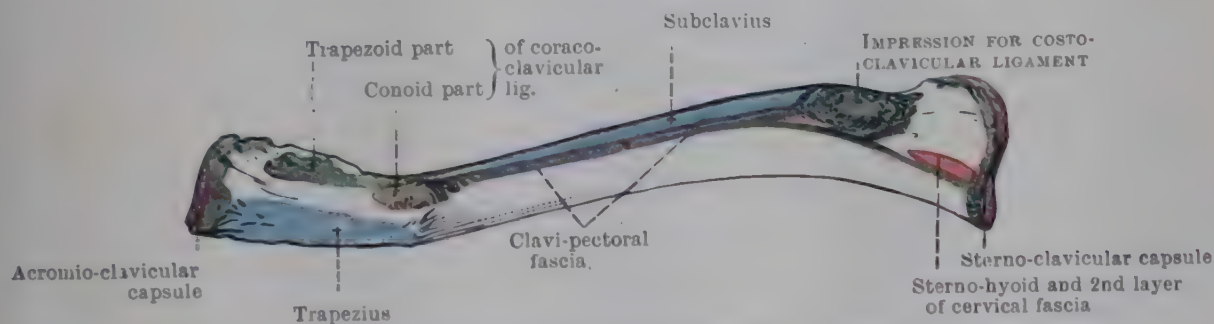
POSTERIOR ASPECT OF RIGHT CLAVICLE.
